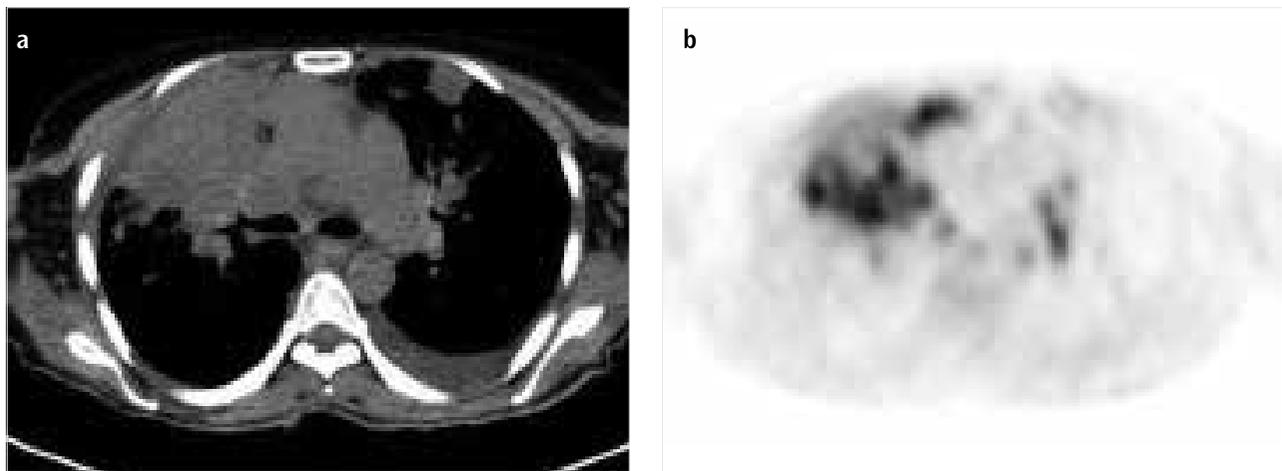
a, b. (a) FDG PET-CT showing metastatic infiltration of the right lung, metastatic paratracheal and hilar lymph nodes, and (b) nodular metastasis on the left lung and left pleural effusion
